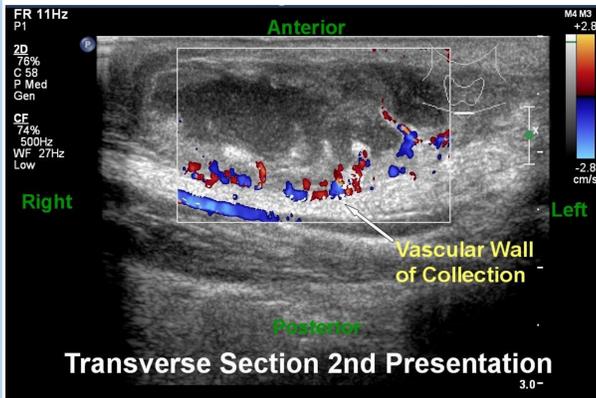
Transverse section of the cystic lesion with colour Doppler
